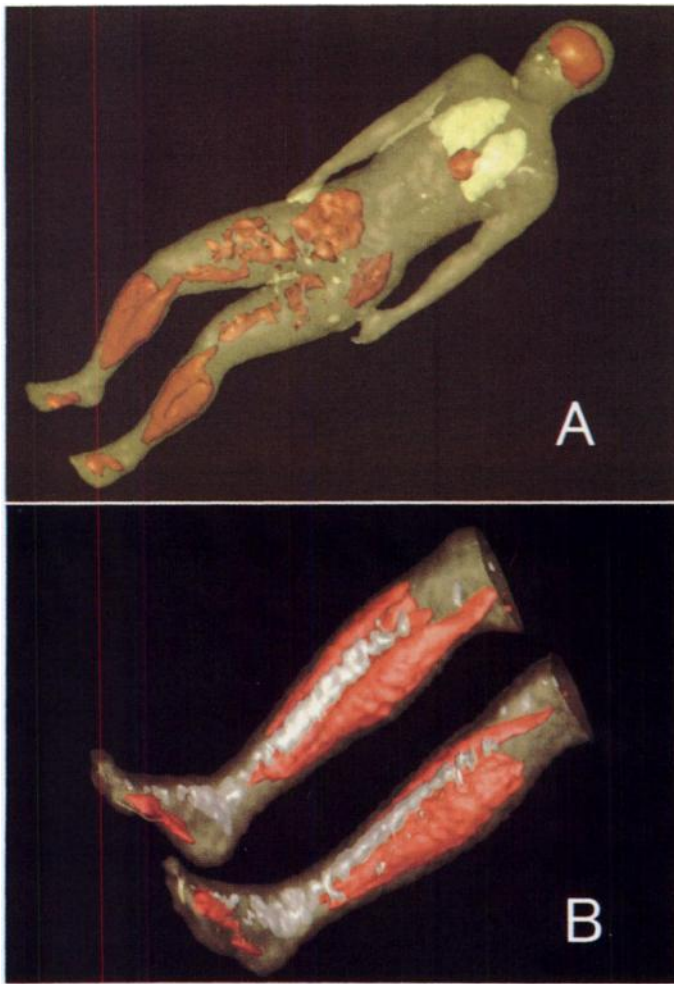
Volume-rendered images of whole body (upper) and (lower) in representative runner. Graphical data of whole-body emission and transmission scans were processed together into "volume rendered images" by AVS Medical Viewer, presented by AVS (Application Visualization System). Red color denotes high FDG uptake in brain, heart and lower extremities. White shows very low uptake areas that are compatible to tibia and bones of feet.
